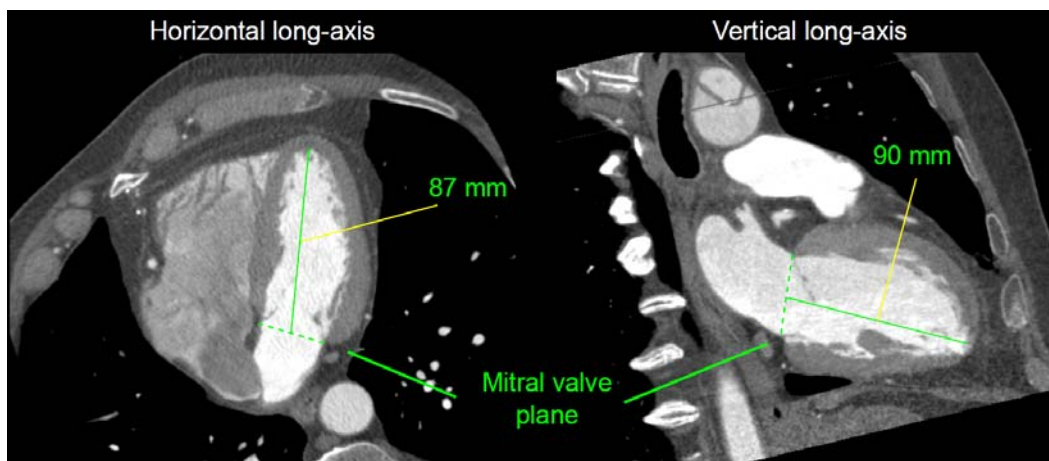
Example of mitral valve plane localization in contrast-enhanced coronary computed tomography angiography. Inner left ventricular length measured from the apex in the endocardial wall to the blood-pool centroid in the valve plane was measured in horizontal and vertical long-axis views from ungated stress MPI images. The average value (88.5 mm) was obtained for this subject.
